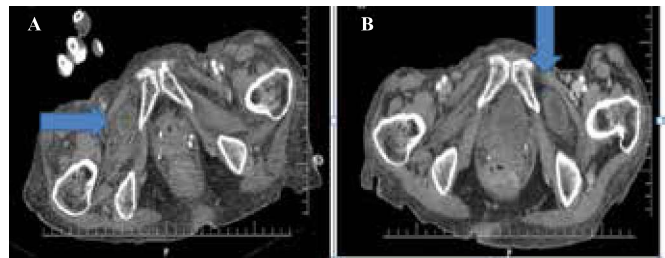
(A) Abdominal computed tomography (CT) scan, right obturator hernia (OB); (B) Abdominal CT scan, left OB.
